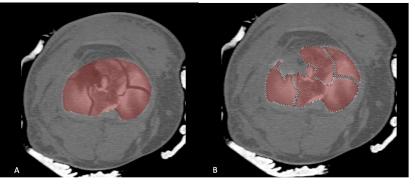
demonstrating an axial CT scans at 3mm slice (A) outlining the expected normal tibial articular surface and (B) subtraction of any absent/depressed/comminuted articular segments of the joint.
